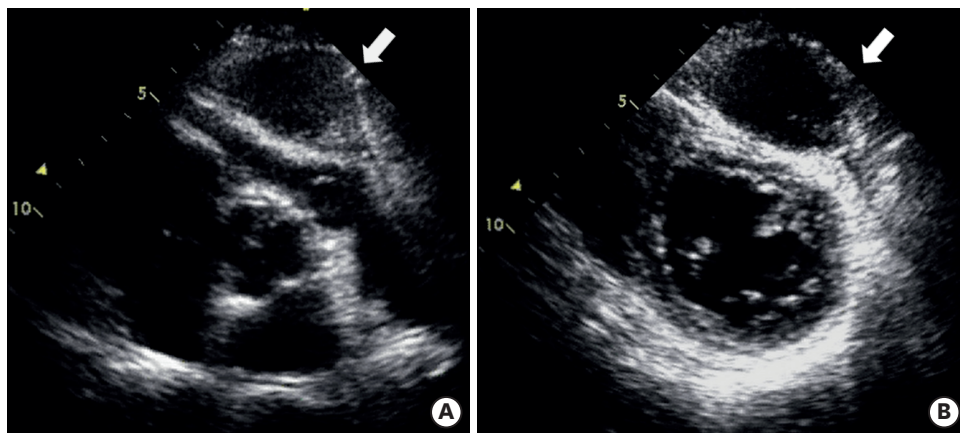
Parasternal short-axis view showed a large, smooth, anechoic mass on the anterior side of the pulmonary artery and left ventricle (arrows). (A) Aortic valve level; (B) mitral valve level.
